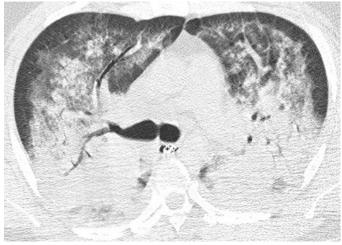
Chest computed tomography image of a patient with bilateral acute respiratory distress syndrome (ARDS). As seen, there is a gradient of infiltrates that worsens progressively from anterior to posterior. The cause of ARDS in this case was indirect due to septic shock from an extrapulmonary (intra-abdominal) source. (From Elicker BM, Jones KT, Naeger DM, et al: Imaging of acute lung injury, *Radiol Clin N Am* 54:1119–1132, 2016.)
